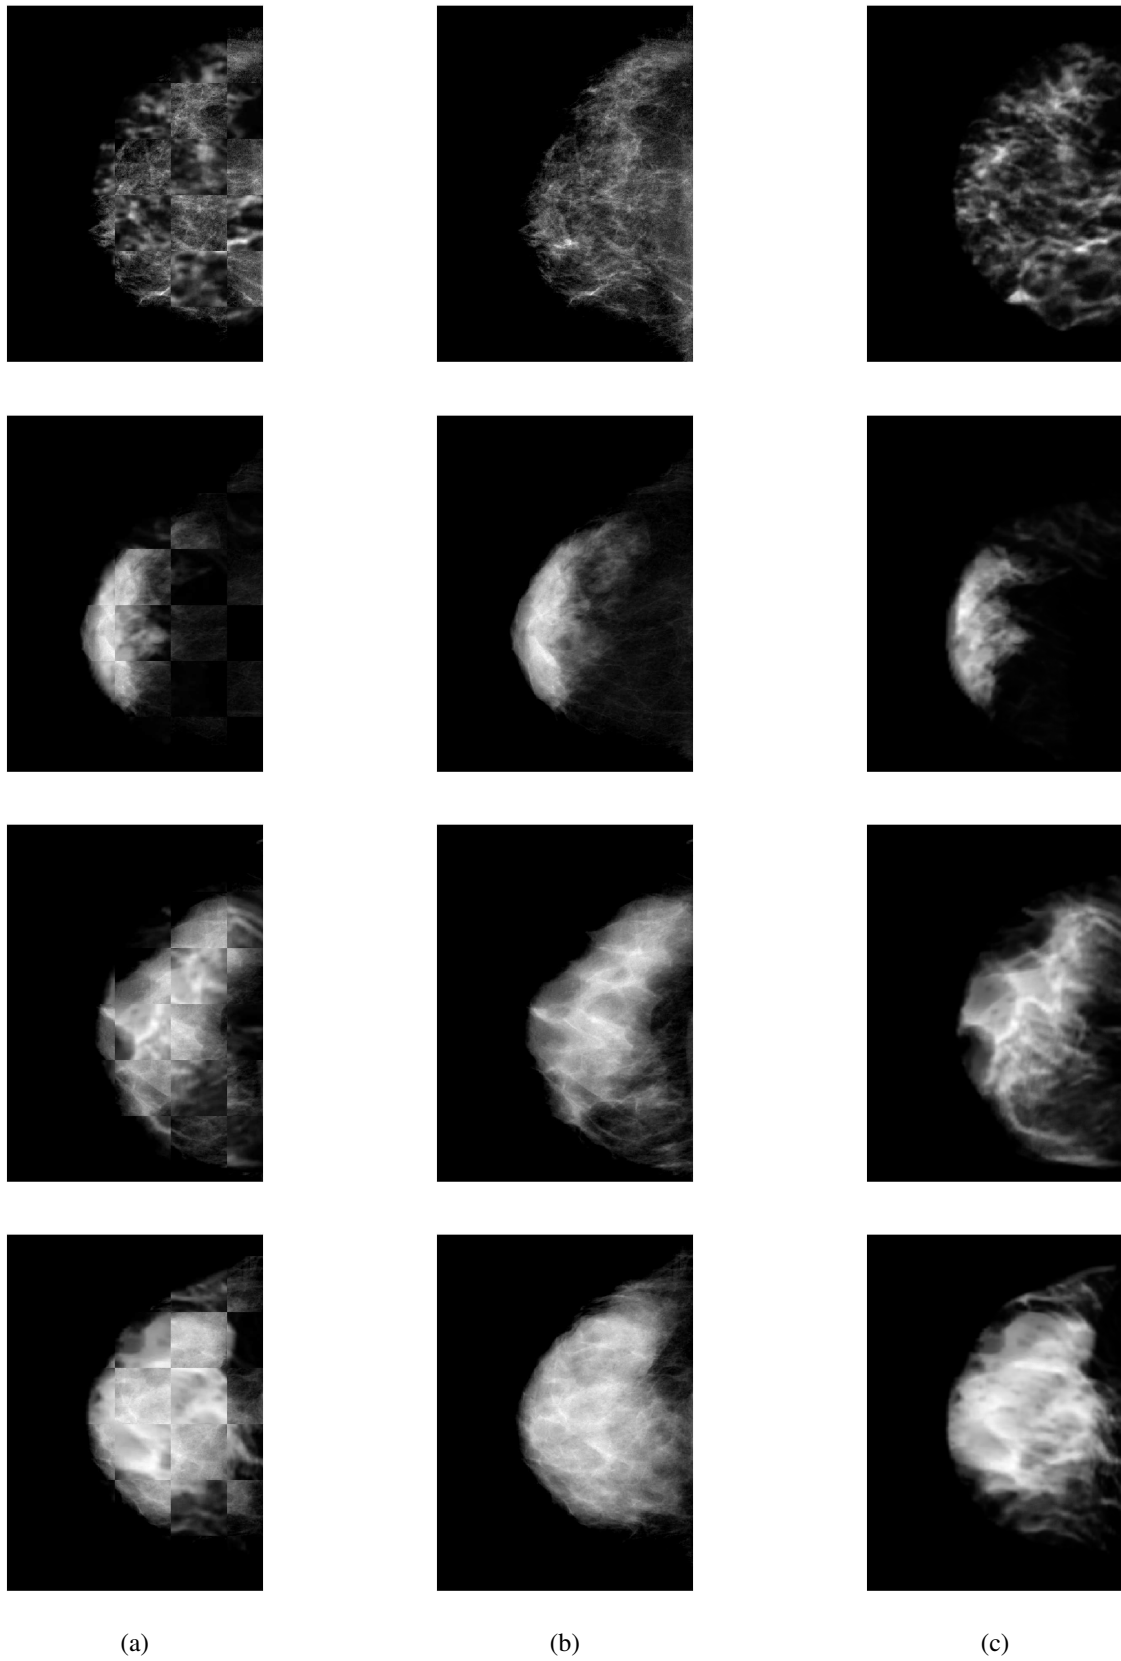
(a) Checkerboard mosaic composed of (b) the VolparaTM and (c) the synthetically obtained from MRI images density maps. Each row corresponds to an increasing BI-RADS category, from BI-RADS 1 to 4.
